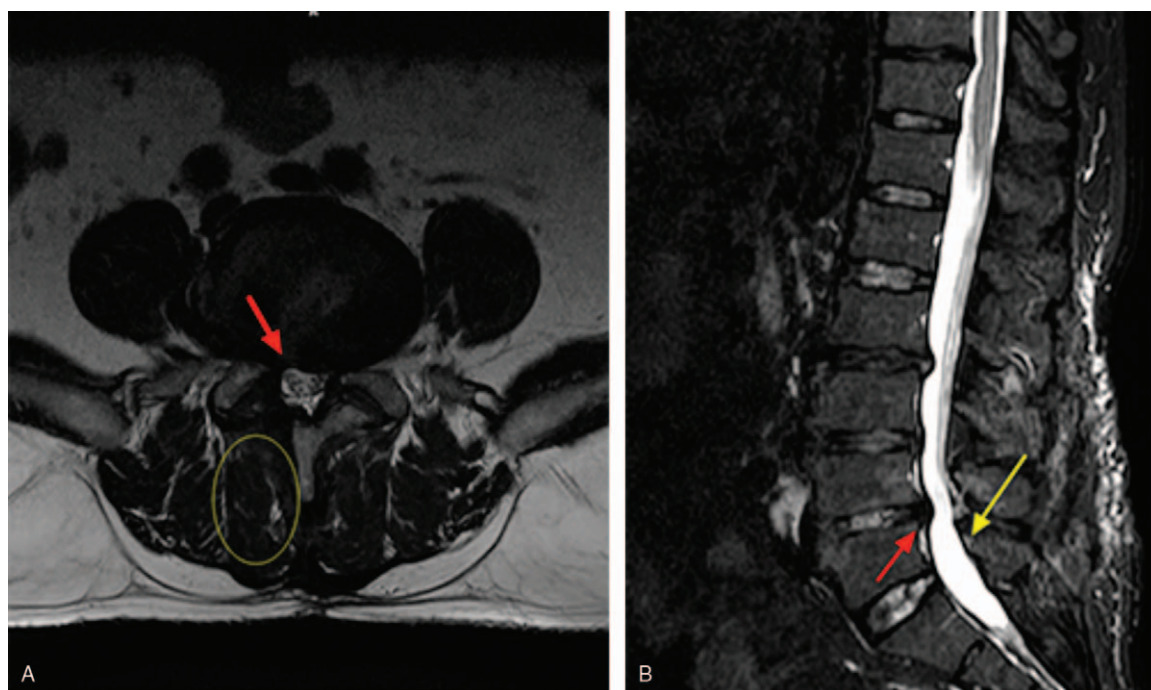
At 6-month follow-up, axial (A) and sagittal (B) MRIs show herniated lumbar disc has been removed and no residual abscess. (Red arrow indicates herniated disc has been removed. Yellow circle and yellow arrow indicates no residual abscess). MRI=magnetic resonance imaging.
